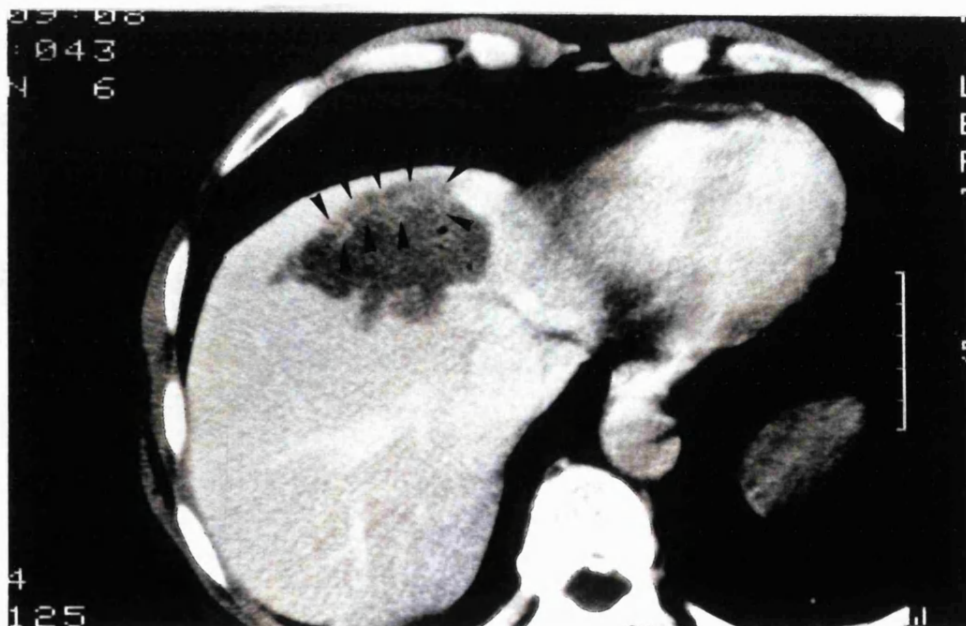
A contrast enhanced CT scan showing a poorly enhancing 5 cm metastasis (arrowed) in the right hepatic lobe prior to treatment. A non-enhancing central portion is suggestive of cystic degeneration.*
